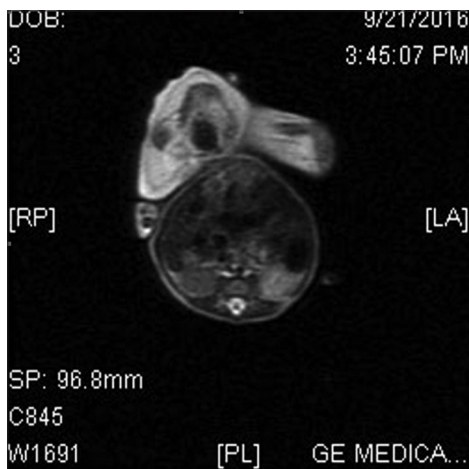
T2 axial magnetic resonance imaging image is showing the dependent fetus with its limb attach to abdominal wall
